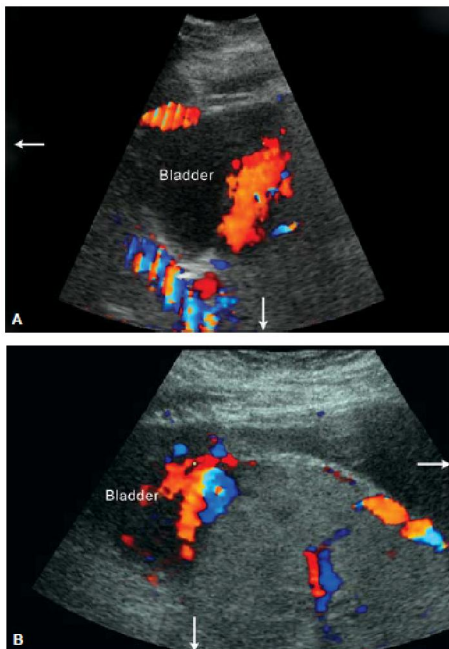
Color Doppler US Images (A,B) show large vessels at the bladder base which cross the placenta
